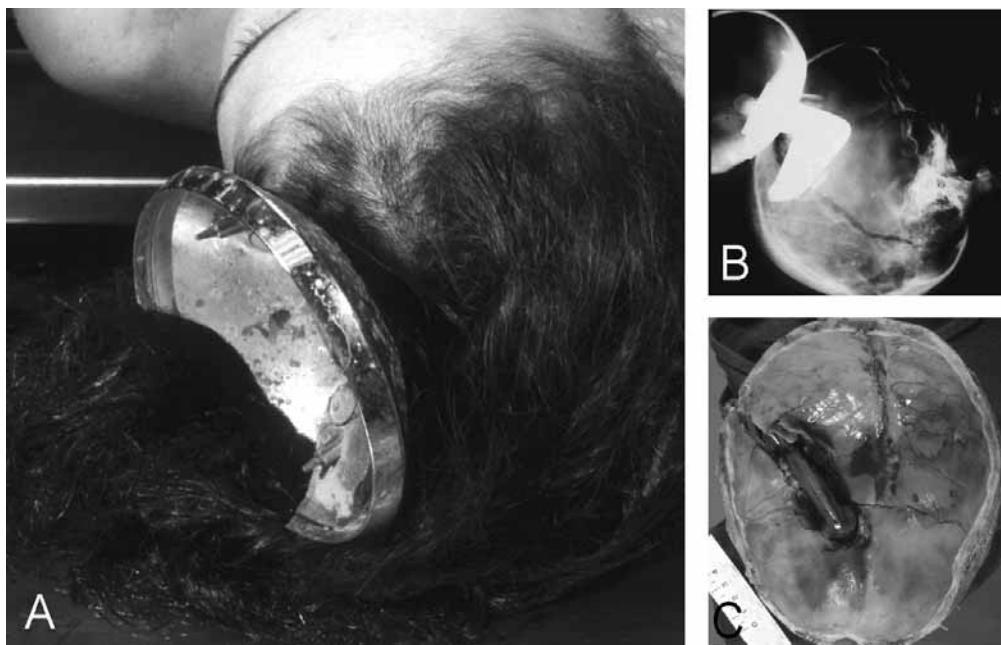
Motor vehicle collision. (A) Impalement by car mirror. (B) Radiograph of skull. (C) Penetration of calvarium.
